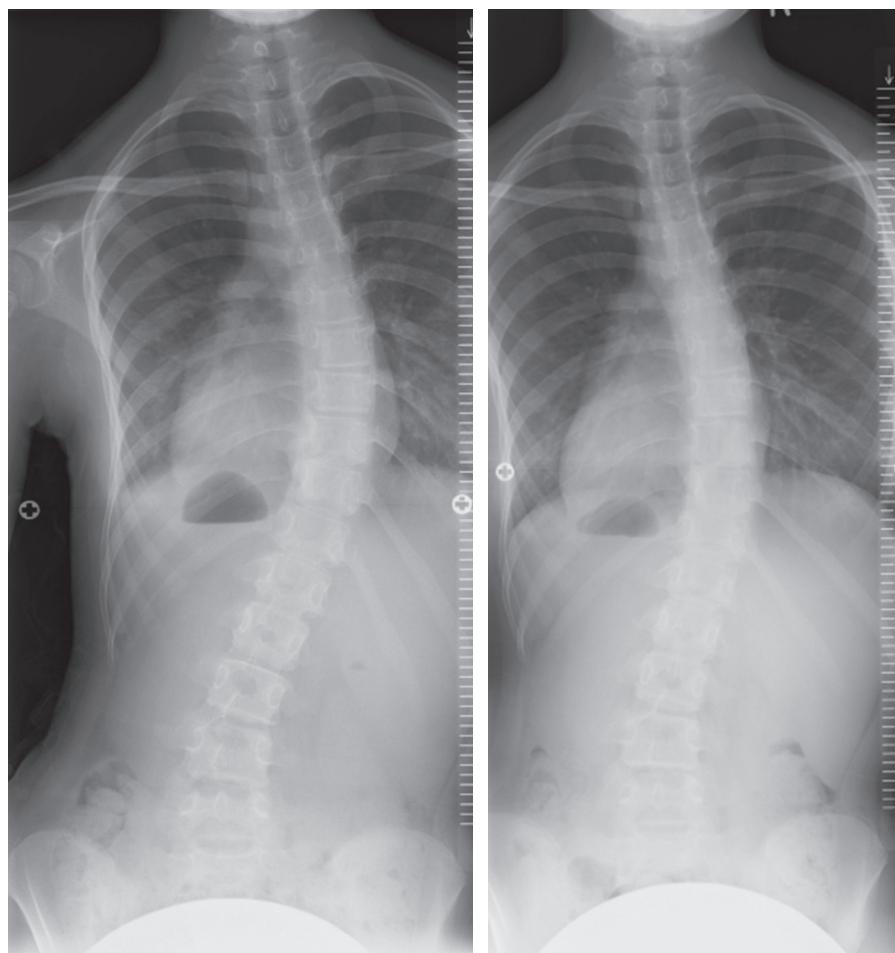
(Left) Whole spine radiographs showed a Lenke type 1AN curve with a Cobb angle of 45°. (Right) Cobb angle had improved to 30° at 5 months postoperation.
